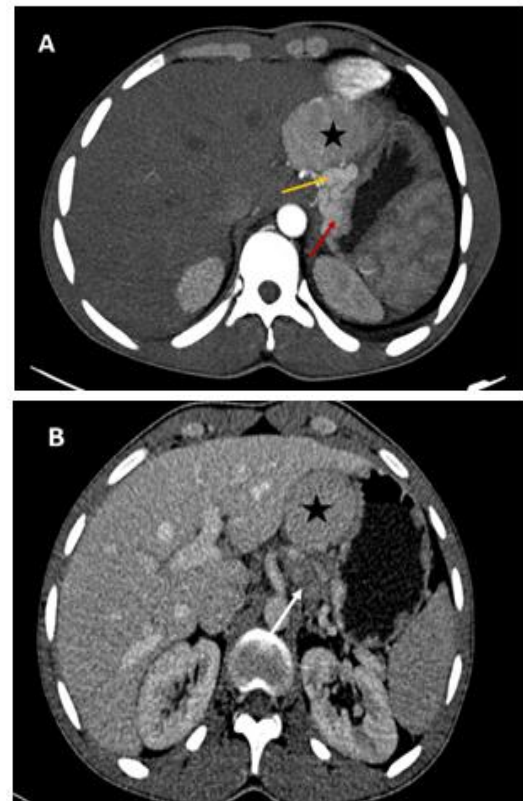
Axial abdominal CT angiography (in the arterial (A) and portal phase (B)) revealed the presence of a well limited mass (asterisk) developed at the expense of the lesser omentum, with regular contours, intensively and heterogeneously enhances in the arterial phase with homogenization at portal phase, producing a compression of the left gastric vein (yellow arrow) and gastric varices (red arrow). We also notice the presence of loco regional lymph nodes (white arrow)
